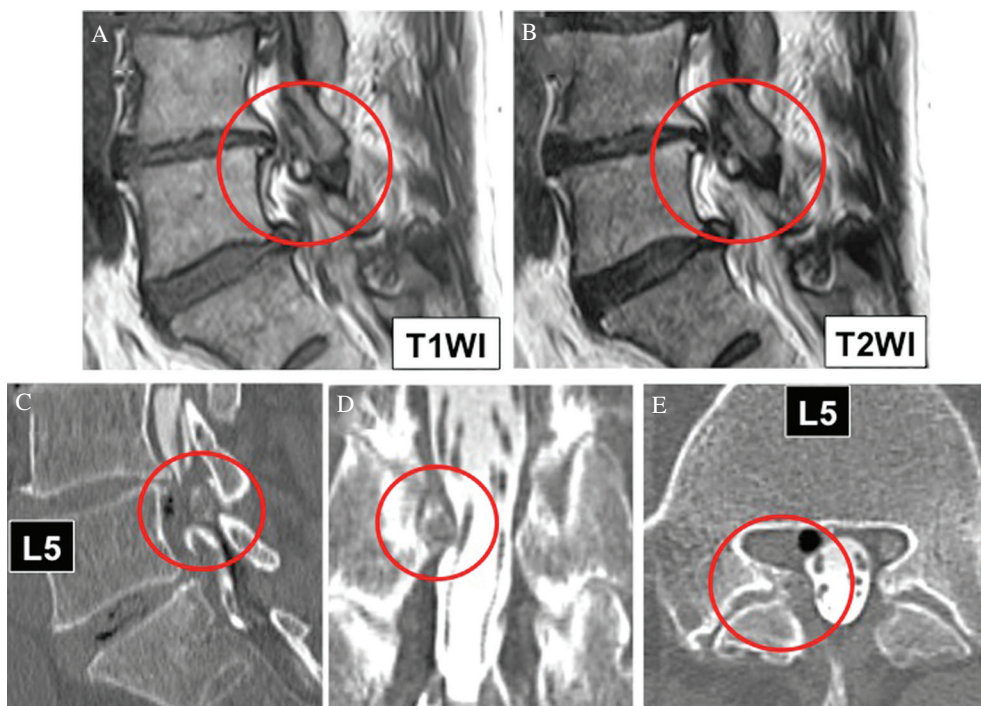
(A and B) Magnetic resonance scans for case 2. (A) T1WI sagittal view. (B) T2WI sagittal view. A small mass can be seen arising from the L5 lamina that shows as a hyperintense area on both T1WI and T2WI and is covered by a hypointense lesion on both T1WI and T2WI (red circle). Computed tomographic myelogram, (C) sagittal view, (D) coronal view, (E) axial view, shows a mass arising from the right L5 superior articular process and compressing the dura mater.
